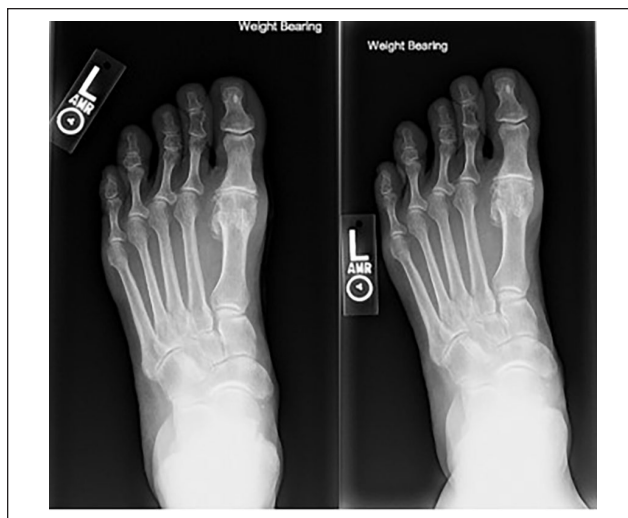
Preoperative (left) and PC postoperative (right) anteroposterior weightbearing radiograph. (PC, percutaneous cheilectomy.)
